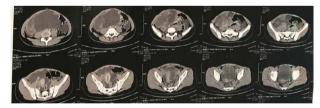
Total abdomen CT (July 2022) showing a large heterogeneous mass, predominantly cystic, with solid components, well delimited margins, and multiple coarse septa in between
